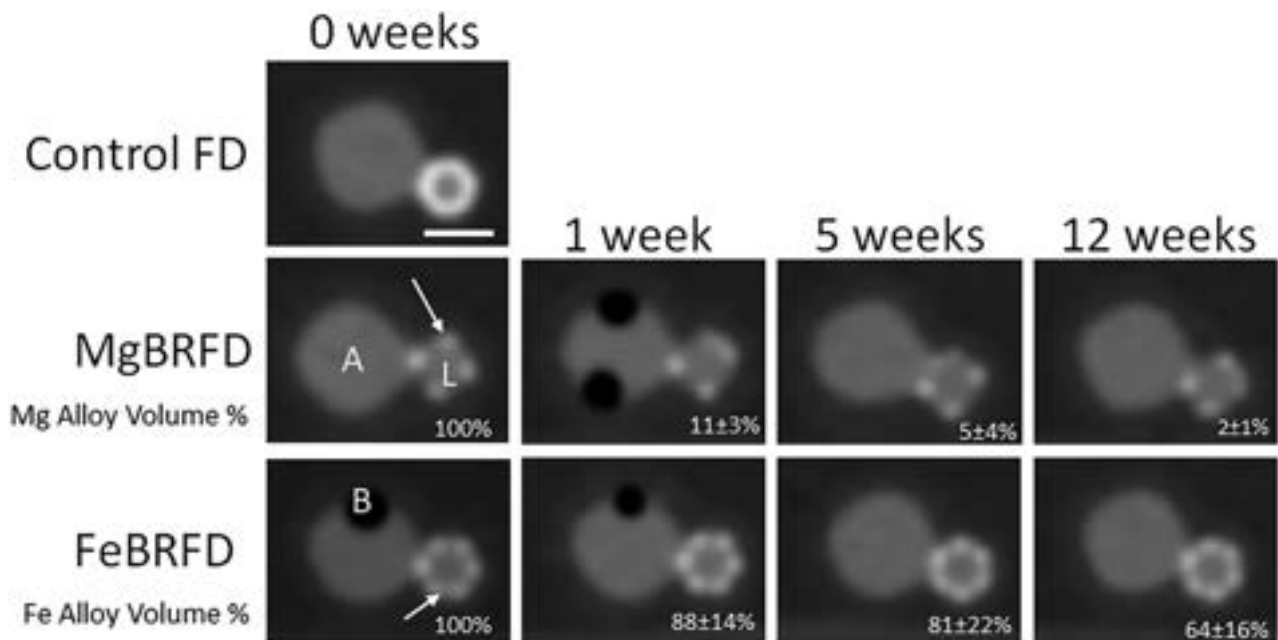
Representative CT images of the control FD, MgBRFD, and FeBRFD and reduction in resorbable device volume with time. A represents the aneurysm sac, L represents the lumen of the parent artery, and B represents trapped air bubbles. The arrows indicate examples of crossing tantalum marker wires. The scale bar is 5 mm.
